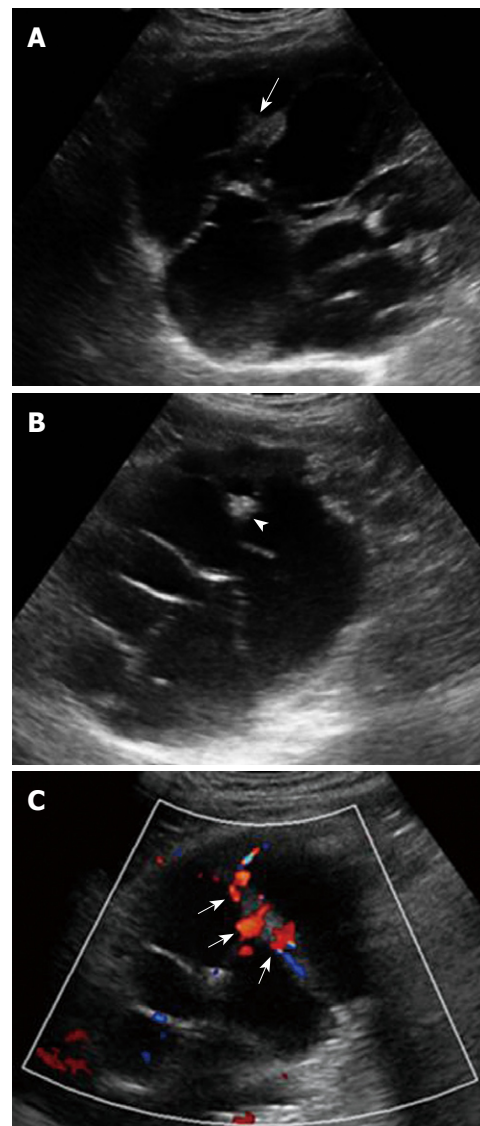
Biliary cystadenocarcinoma. A: Conventional sonography shows a multilocular cystic lesion in left lobe of the liver with nodular thickening of internal septa and mural nodules projecting into the cyst (arrow); B: Conventional sonography shows septal calcifications or stones (arrowhead); C: Color doppler flow imaging (CDFI) shows affluent vascularity in the internal septa (arrows).
